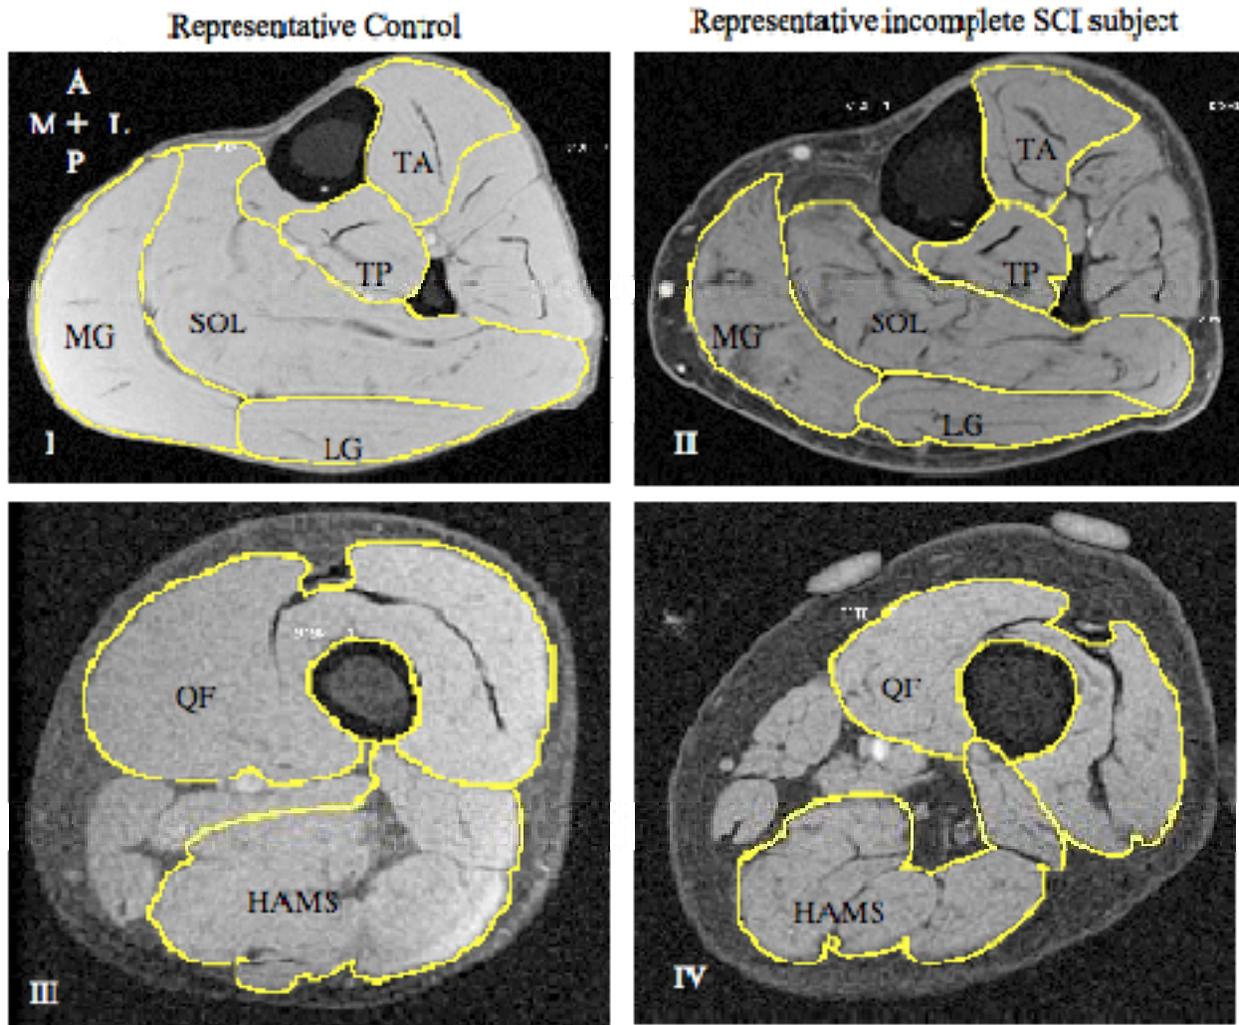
Representative trans-axial proton magnetic resonance images obtained at 1.5Tesla magnetic field. Leg (I, II) and thigh (III, IV) in a subject with incomplete-SCI (right) and corresponding age-matched control (left). [A= anterior; P = posterior; M=medial; L=lateral; MG=medial gastrocnemius; LG= lateral gastrocnemius; SOL=soleus, TP=tibialis posterior; TA=tibialis anterior, QF=quadriceps; HAMS=hamstrings].
